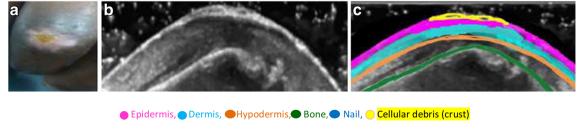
a Clinical image of non-ulcer lesions with irregular skin depression. b Sonographic image showing irregular hyperechoic tissue above the level of surrounding epidermis. c Colored figure showing irregular yellow tissue above the level of epidermis
